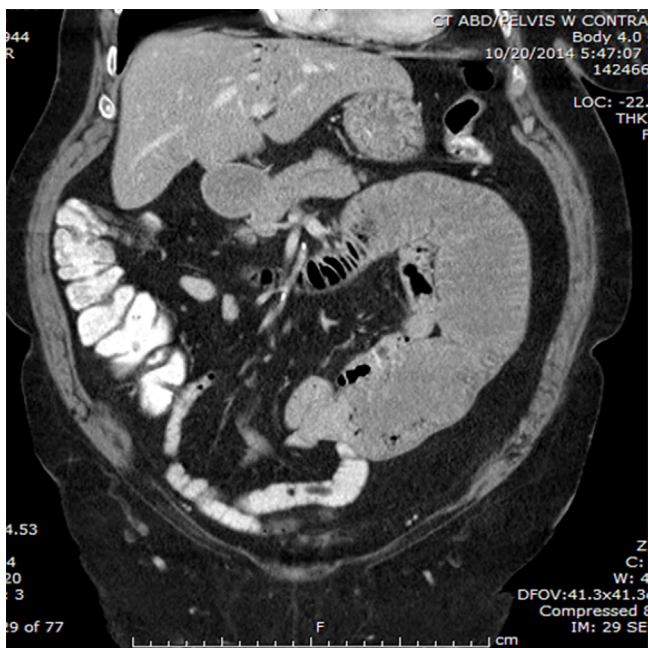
CT scan showing small bowel obstruction.
